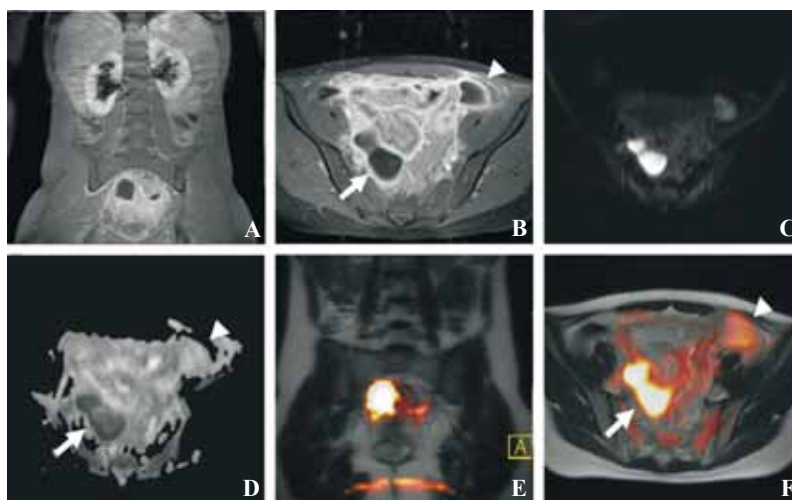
Patient 11, diffuse peritonitis in the lower abdomen secondary to perforated appendicitis. Two ring-enhancing lesions are discernable (arrow, arrowhead). DWI differentiates between the posteriorly located abscess (arrow, ADC $0.76 \times 10^{-3} \text{ mm}^2/\text{s}$) and the anterior non-purulent collection (arrowhead, ADC $2.45 \times 10^{-3} \text{ mm}^2/\text{s}$), as confirmed by surgery. Coronal (A) and transversal (B) post-contrast T1 TSE FS, transversal DWI $b=800$ (C), ADC map (D), 3D image fusion of corresponding coronal (E) and transversal (F) T2 HASTE with coloured half-transparent overlay of transversal DWI $b=800$.
